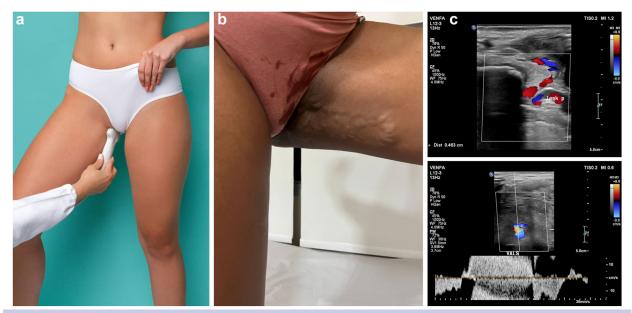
A, Location of the perineal escape point on transperineal ultrasound examination. B, Varicose veins in the perineal region and root of the thigh. C, Perineal escape point with reflux on color Doopler. Authors archive.
